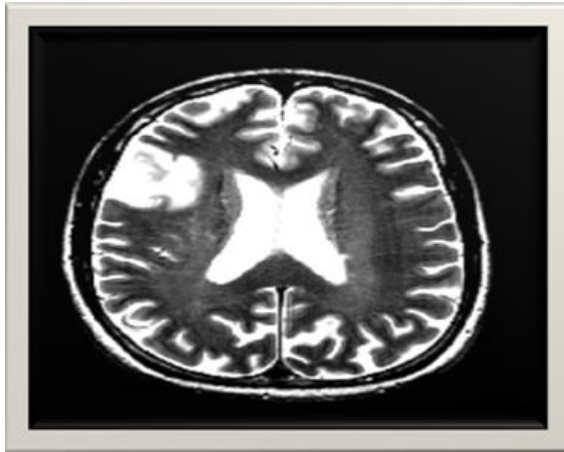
MRI brain tumors post gadolinium axial FSE.
